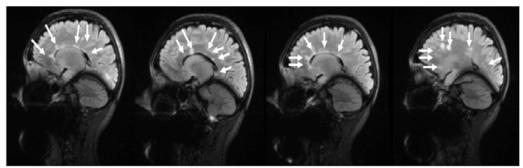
Simple brain magnetic resonance imaging. T2-weighted sequence showing periventricular and pericallosal hyperintense lesions related to demyelinating disease. Source: Images obtained while conducting the study. Archives of the Radiology Service of the Hospital Militar Central.
